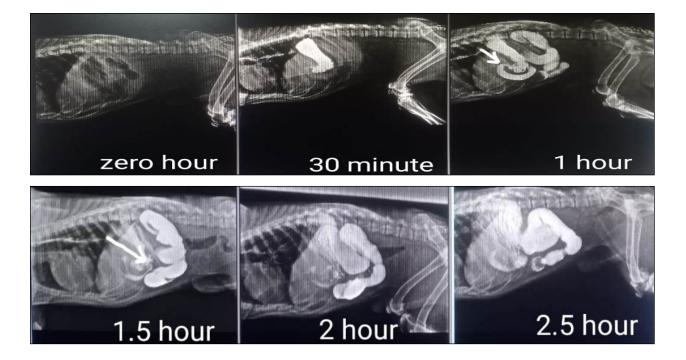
Shows the contrast radiography (Barium contrast radiography) to diagnose the blockage or stenosis of the GIT tract, arrow shows the stenosis of duodenum and intestine also block by some foreign object
